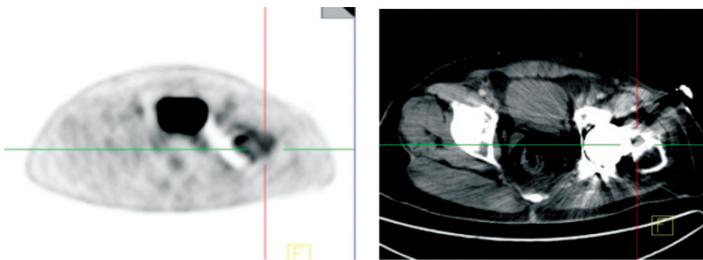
Cross sectional image across the prosthetic hip joints demonstrating high FDG uptake in the left (left). The corresponding CT image (right) suffers from severe beam hardening artefact
